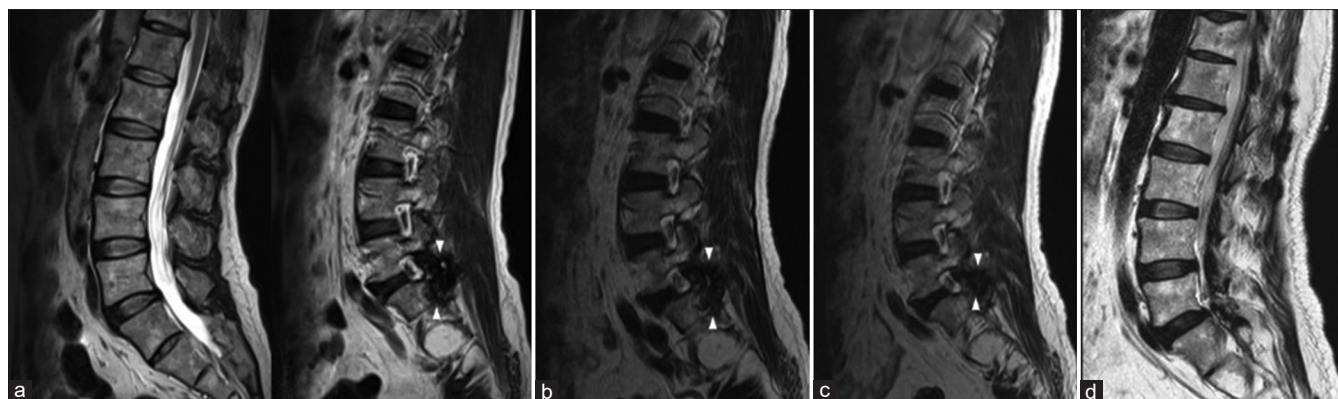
Magnetic resonance imaging of lumbar spine, axial T2-weighted images (a-c), axial T2-weighted fat spin echo (FSE) image (d). (a) Axial magnetic resonance images showing a heterointense mass-like lesion (arrowheads) located in the posterolateral spinal canal around left L5/S1 facet joint with left S1 root compression (arrows). (b and c) Gradual resolution of hematoma was observed at 3 months (b) and 9 months (c) after conservative treatment. (d) The axial image shows complete resolution of hematoma at 4-year follow-up
